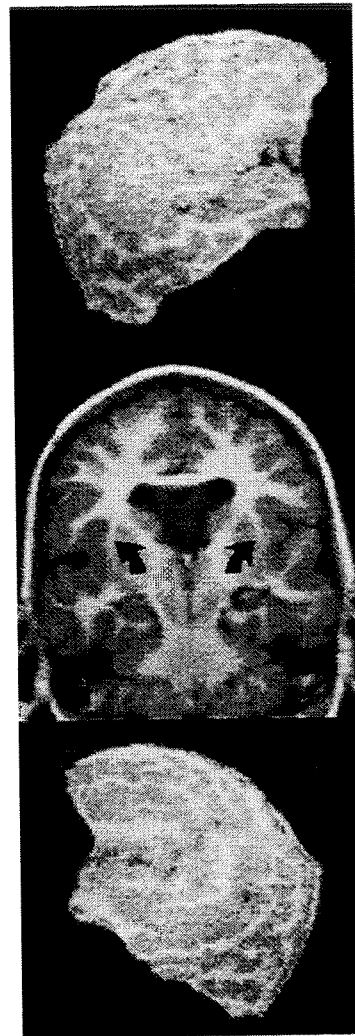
(Patient 12). Curvilinear reformatting from 12 mm of depth from the cortical surface and coronal T1/IR image (thickness = 3 mm) showing diffuse polymicrogyria around the perisylvian fissure. Note that thin slices and image postprocessing techniques improve the visual display of subtle lesions on MRI.
